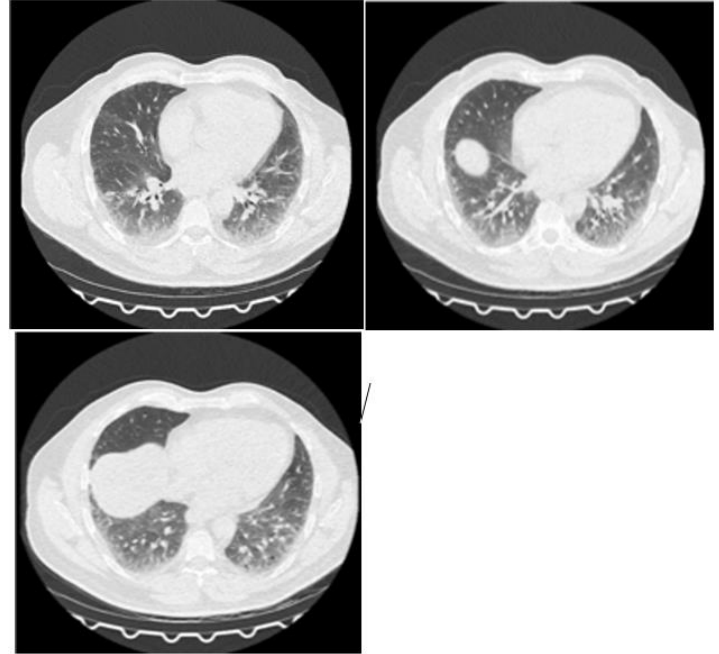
HRCT showing bilateral ground-glass opacities with subpleural and perifissural reticular thickening, along with early honeycombing.
